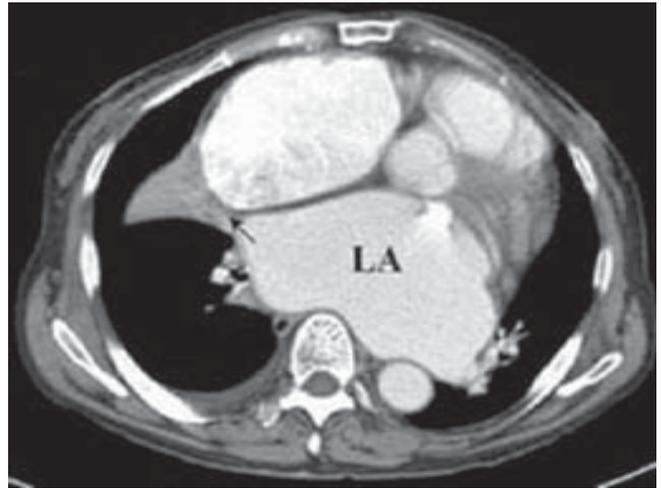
Computed tomographic scan showing left atrial enlargement (LA) and right middle lobe collapse (arrow).
